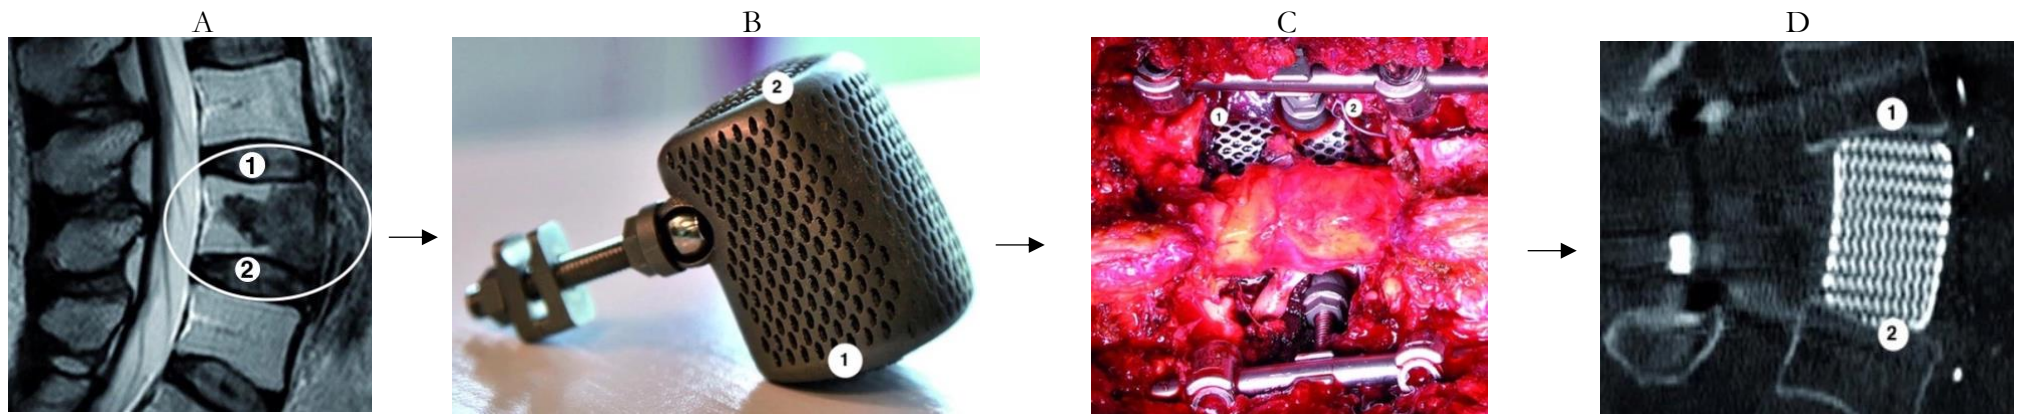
Prosthesis produced in titanium cage is reconstructed to be replaced with the infected vertebra. A: Tumour extension in vertebra, B: Lateral view of the prosthesis in titanium, C: reconstruction of the anterior column during the surgery, D: Coronal CT-scan showing final reconstruction of the anterior column (Girolami et al., 2018).
